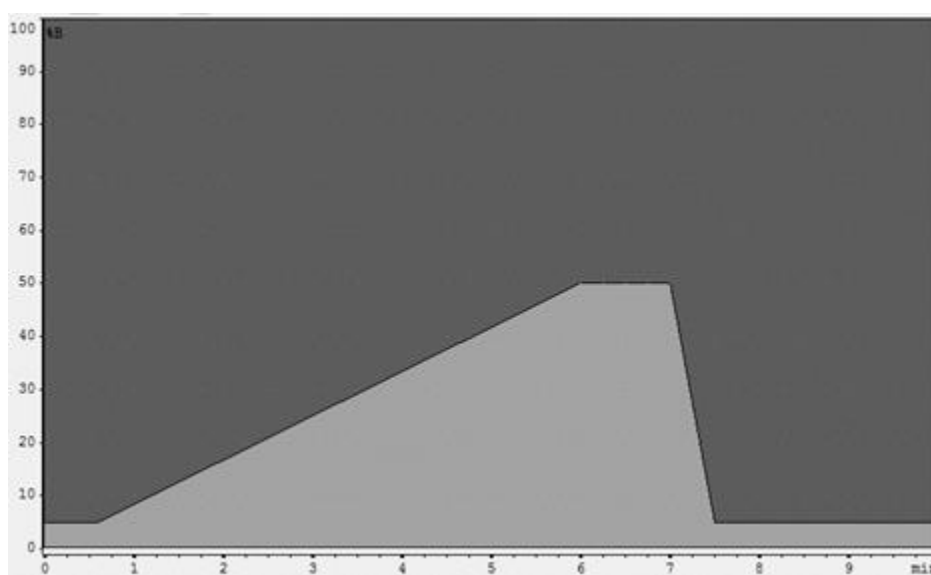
Solvent gradient for the [^{68}Ga]Ga-PSMA-11 and [^{68}Ga]Ga-DOTA-NOC HPLC method: %B is the ACN percentage.
